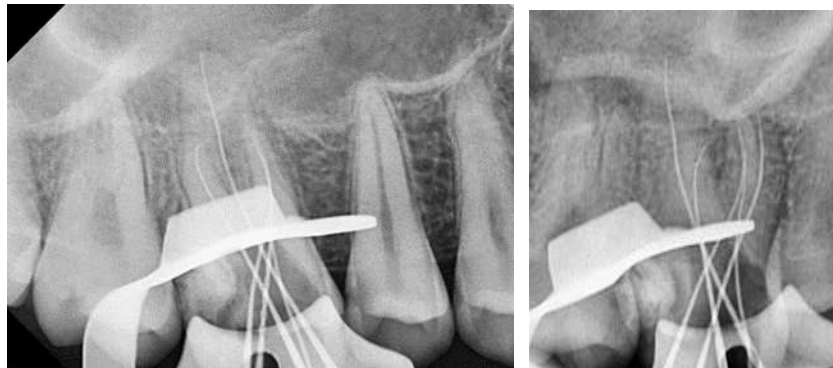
RVG Radiographic images showing Mastercone selection for the canals : MB1, MB2, MB3, DB and P
